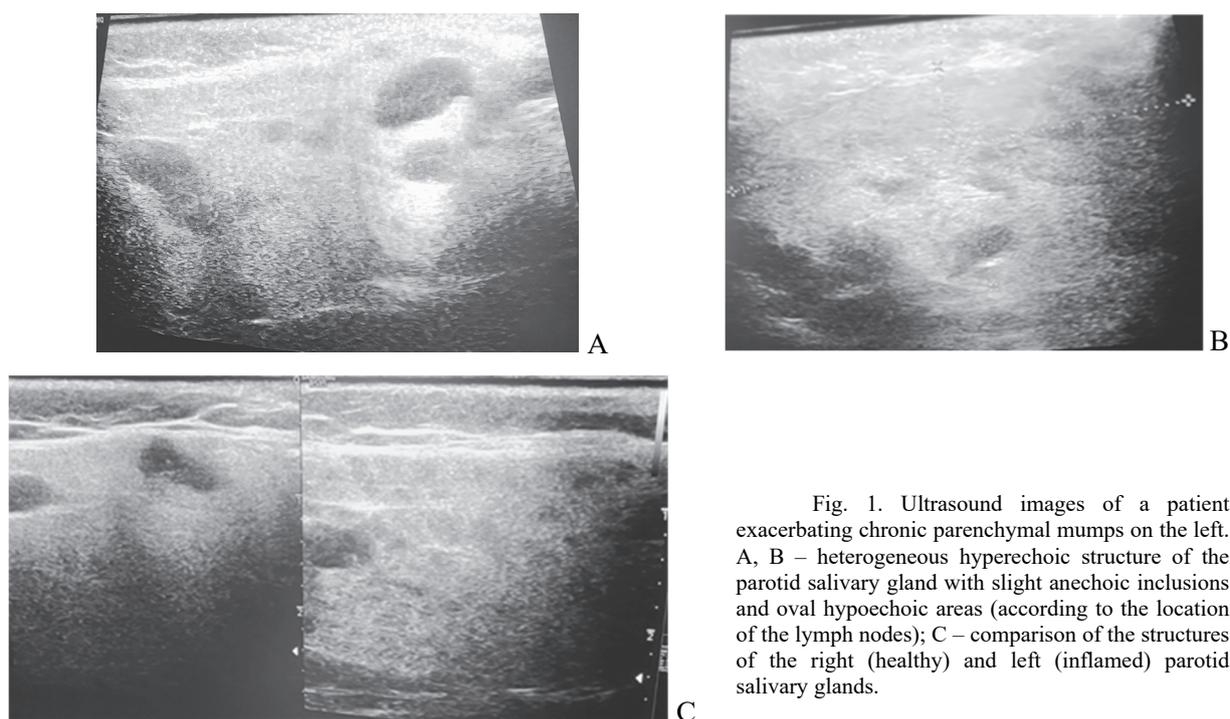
Ultrasound images of a patient exacerbating chronic parenchymal mumps on the left. A, B – heterogeneous hyperechoic structure of the parotid salivary gland with slight anechoic inclusions and oval hypoechoic areas (according to the location of the lymph nodes); C – comparison of the structures of the right (healthy) and left (inflamed) parotid salivary glands.
